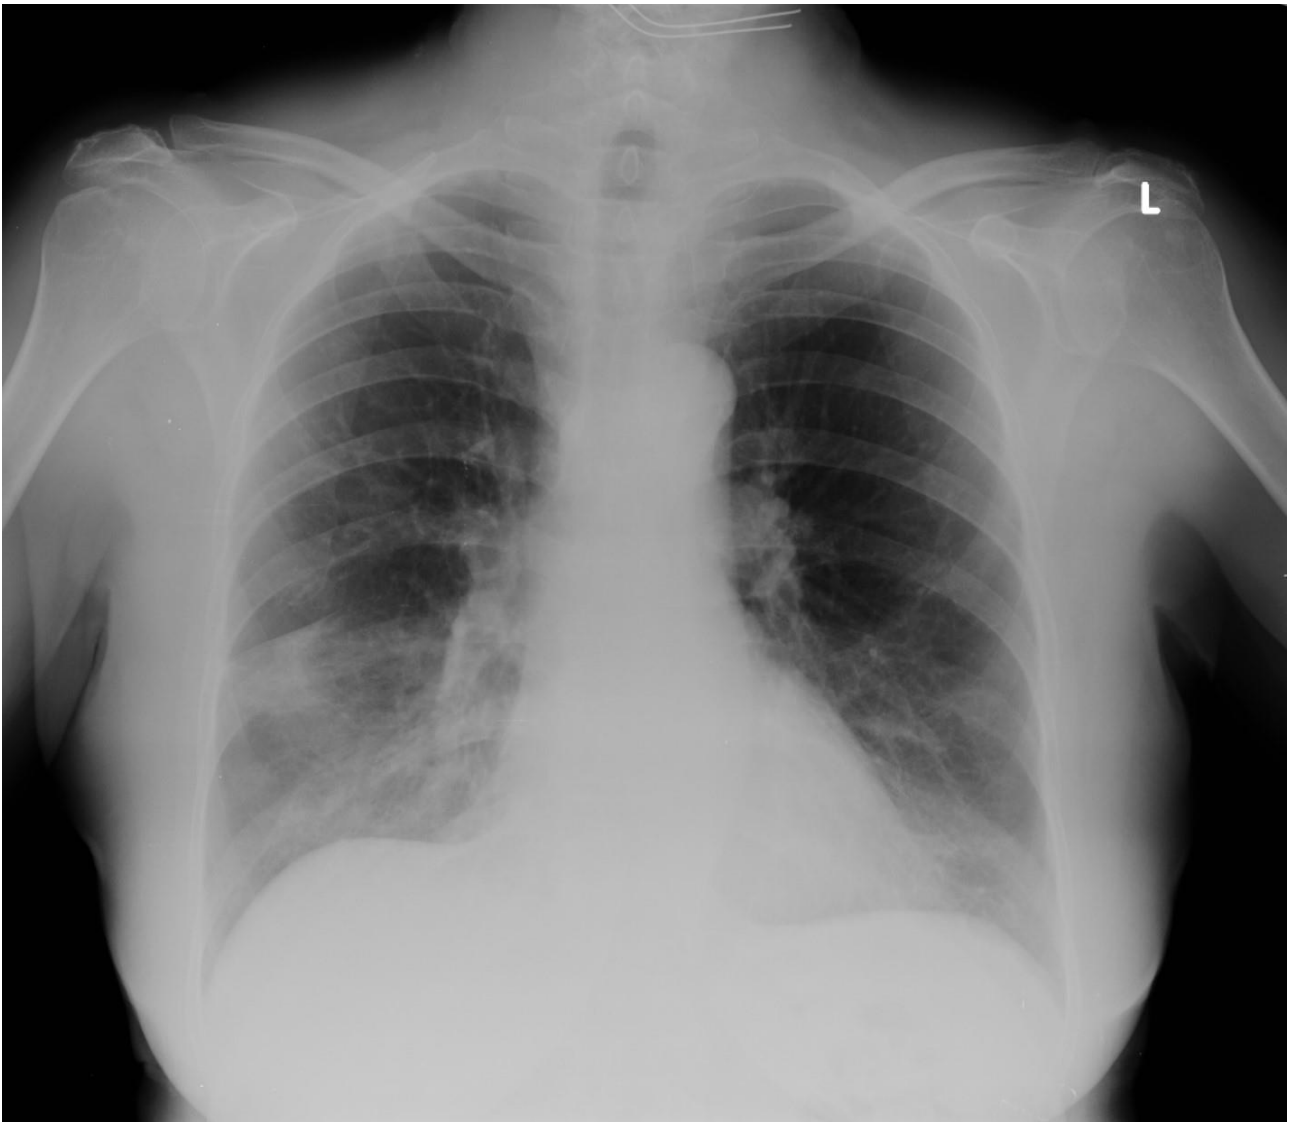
Chest radiograph results at the admission of the patient on 15.03.2020. Bilateral peripheral distribution pneumonia.
